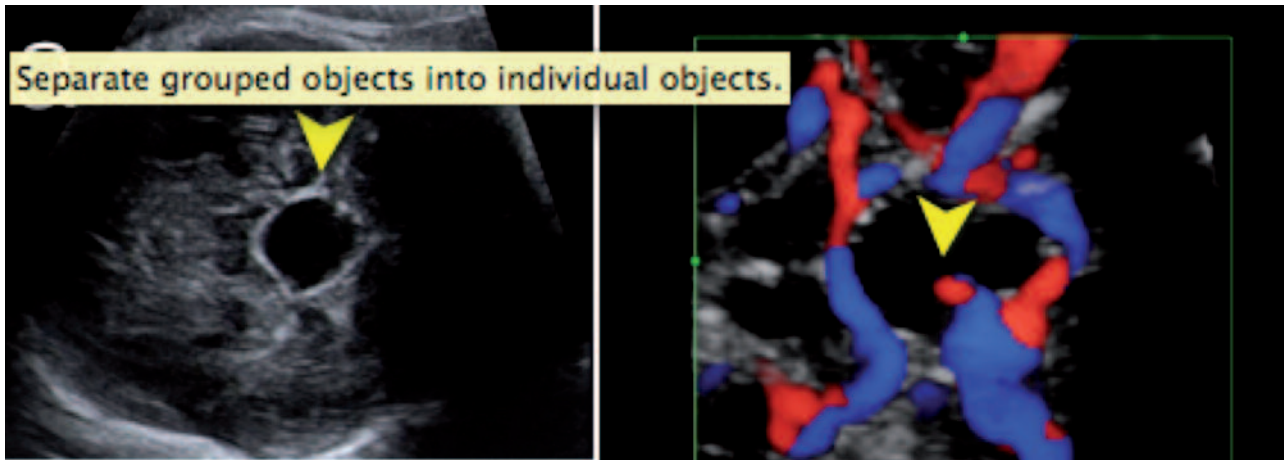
A suprasellar arachnoid cyst (arrow head) exerts pressure of the circle of Willis and the optic chiasma. Power Doppler imaging shows the extension of the circle of Willis at the base of the cyst.
